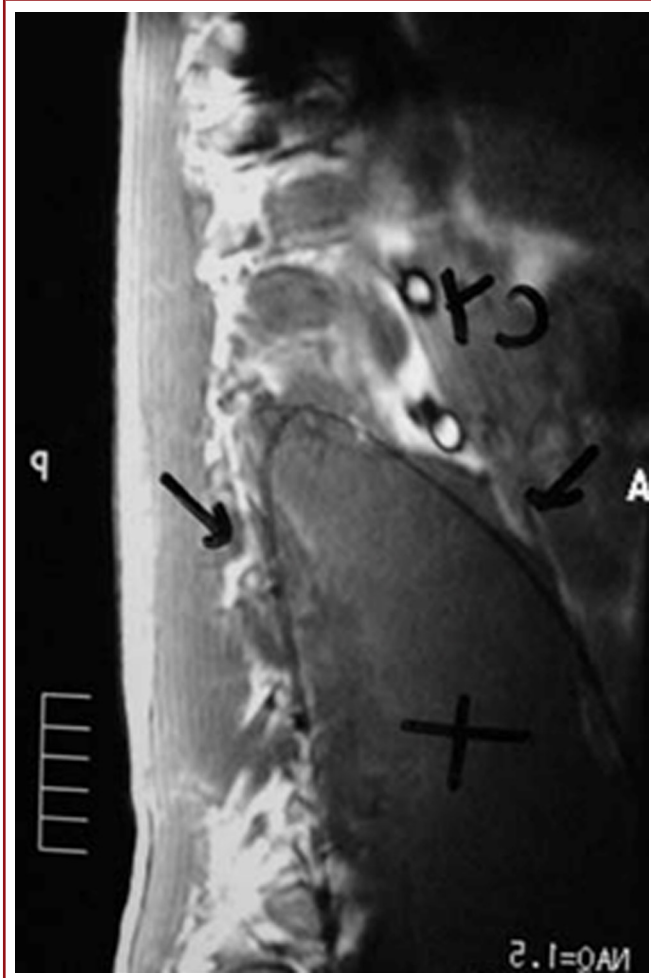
MR images of the patients with spinal tuberculosis and psoas abscess in lumbar vertebrae (From Prof. İ. Teoman Benli's archive).
